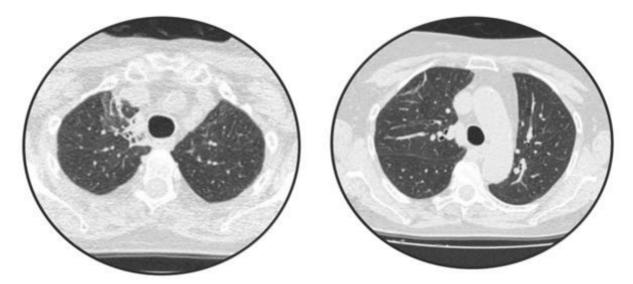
Computed tomography of the chest without contrast, showing an improvement after 3 months.
